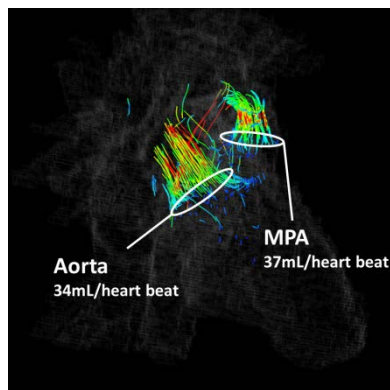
Volume rendered MRA from 4D flow MRI in 6 month-old with congenital pulmonary vein stenosis.
